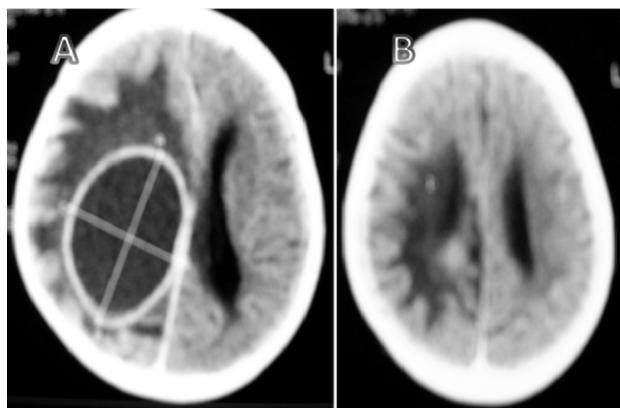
CT scan of head of an 8-year old child presenting with fever and altered sensorium at the time of admission. Post contrast (A) scans showing an area of low density with a marked ring around the low density area. Contrast CT scan of head (B) of the same patient after burrhole aspiration and completion of antibiotics treatment, 6 weeks after admission. Note the complete disappearance of the abscess. Gliosis in the area is evident.
